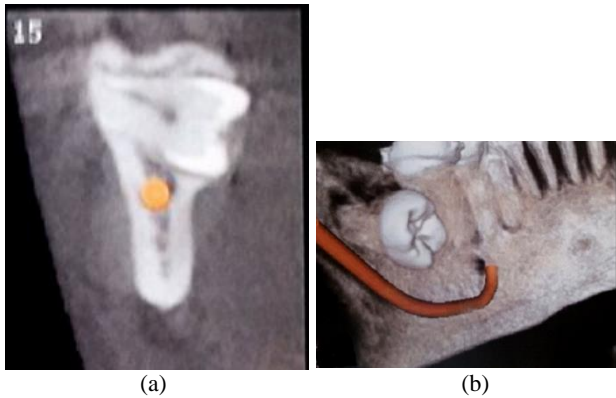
Coronal section (A) and 3D reconstruction (B) of computed tomography (CT). CT scans shows a transversal position of the third mandibular molar with Thinning of the lingual plate
